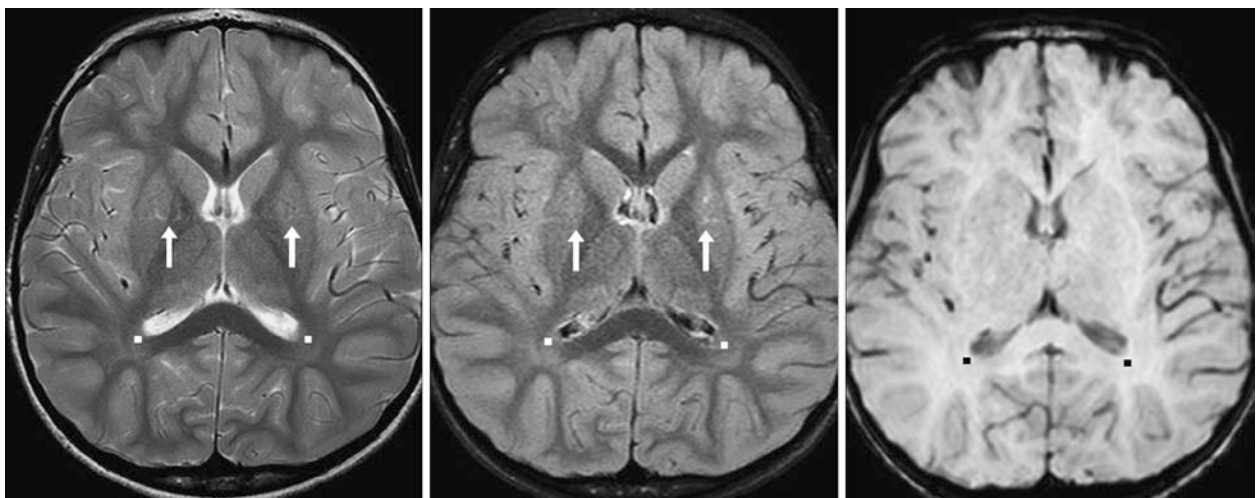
A 3.0-year-old with weakness had a 3T MRI with SE T2WI (*left*), FLAIR (*middle*), and SWI (*right*). There are mild, residual PTWM terminal zones (*squares*), but the rest of the deep WM and PVWM are mature. Note CSF pulsation artifact (*arrows*)
